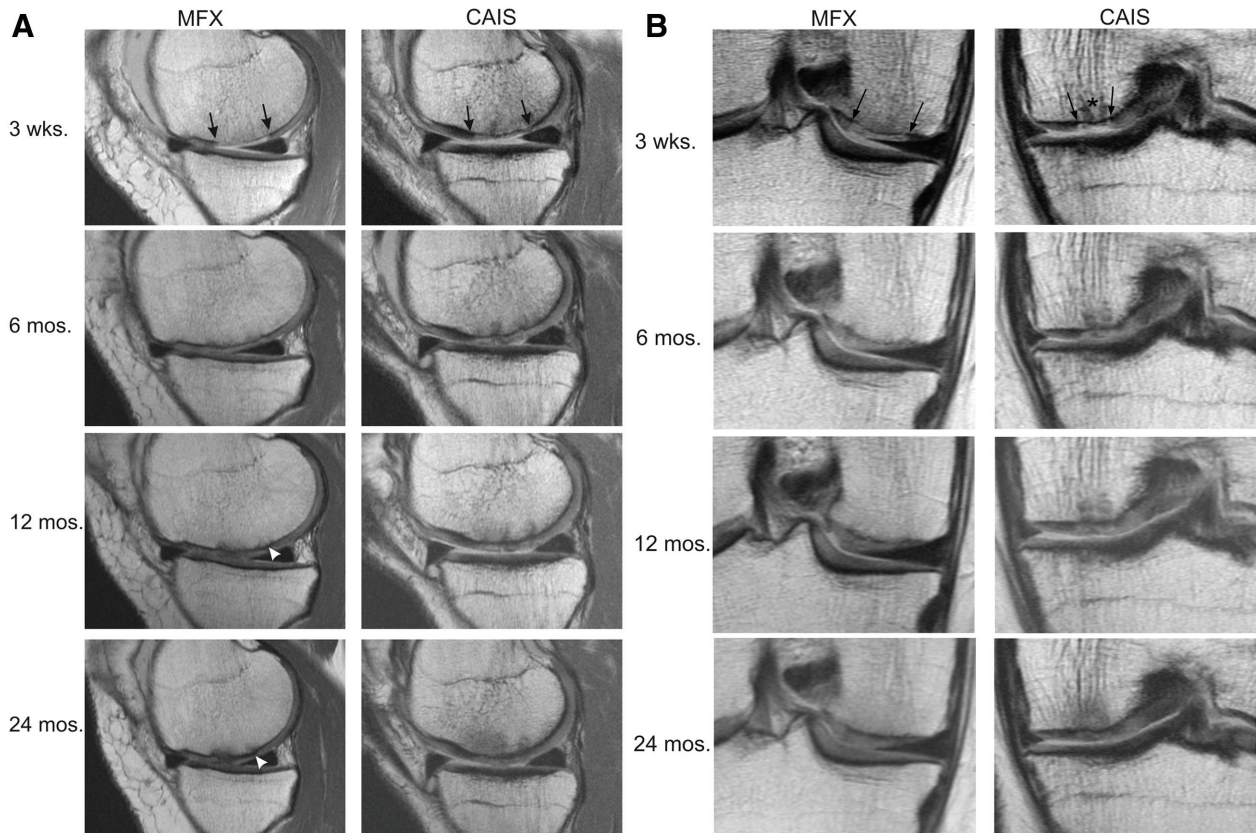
Magnetic resonance images (intermediate-weighted fast spin echo) of 2 representative patients (patient #1001, MFX; patient #2002, CAIS) treated with microfracture (MFX) (A) or Cartilage Autograft Implantation System (CAIS) (B). Repair sites were equivalent in size and located on the medial femoral condyle (between arrows, 3 weeks). At 3 weeks, the repair site in the medial femoral condyle is clearly visible as a high intensity region representative of the early biological processes for MFX and CAIS. The patient treated with CAIS has 2 low intensity structures (medial and lateral to “*” on 3-week image), which diminished on subsequent time points representing the gradually absorbed staples. At 12 and 24 months, an intralesional osteophyte (white arrowheads, A) develops in the patient treated with MFX.
